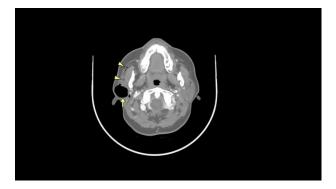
Axial CT scan of the skull base (air window) showed A well-defined air attenuation mass-like lesion (arrow) within the right parotid parenchyma; no solid or cystic component is noted within the lesion. A discontinuous curvilinear air density is seen anterior to the parotid gland at the course of the parotid duct (arrow heads), an indication of air within Stensen's duct.
